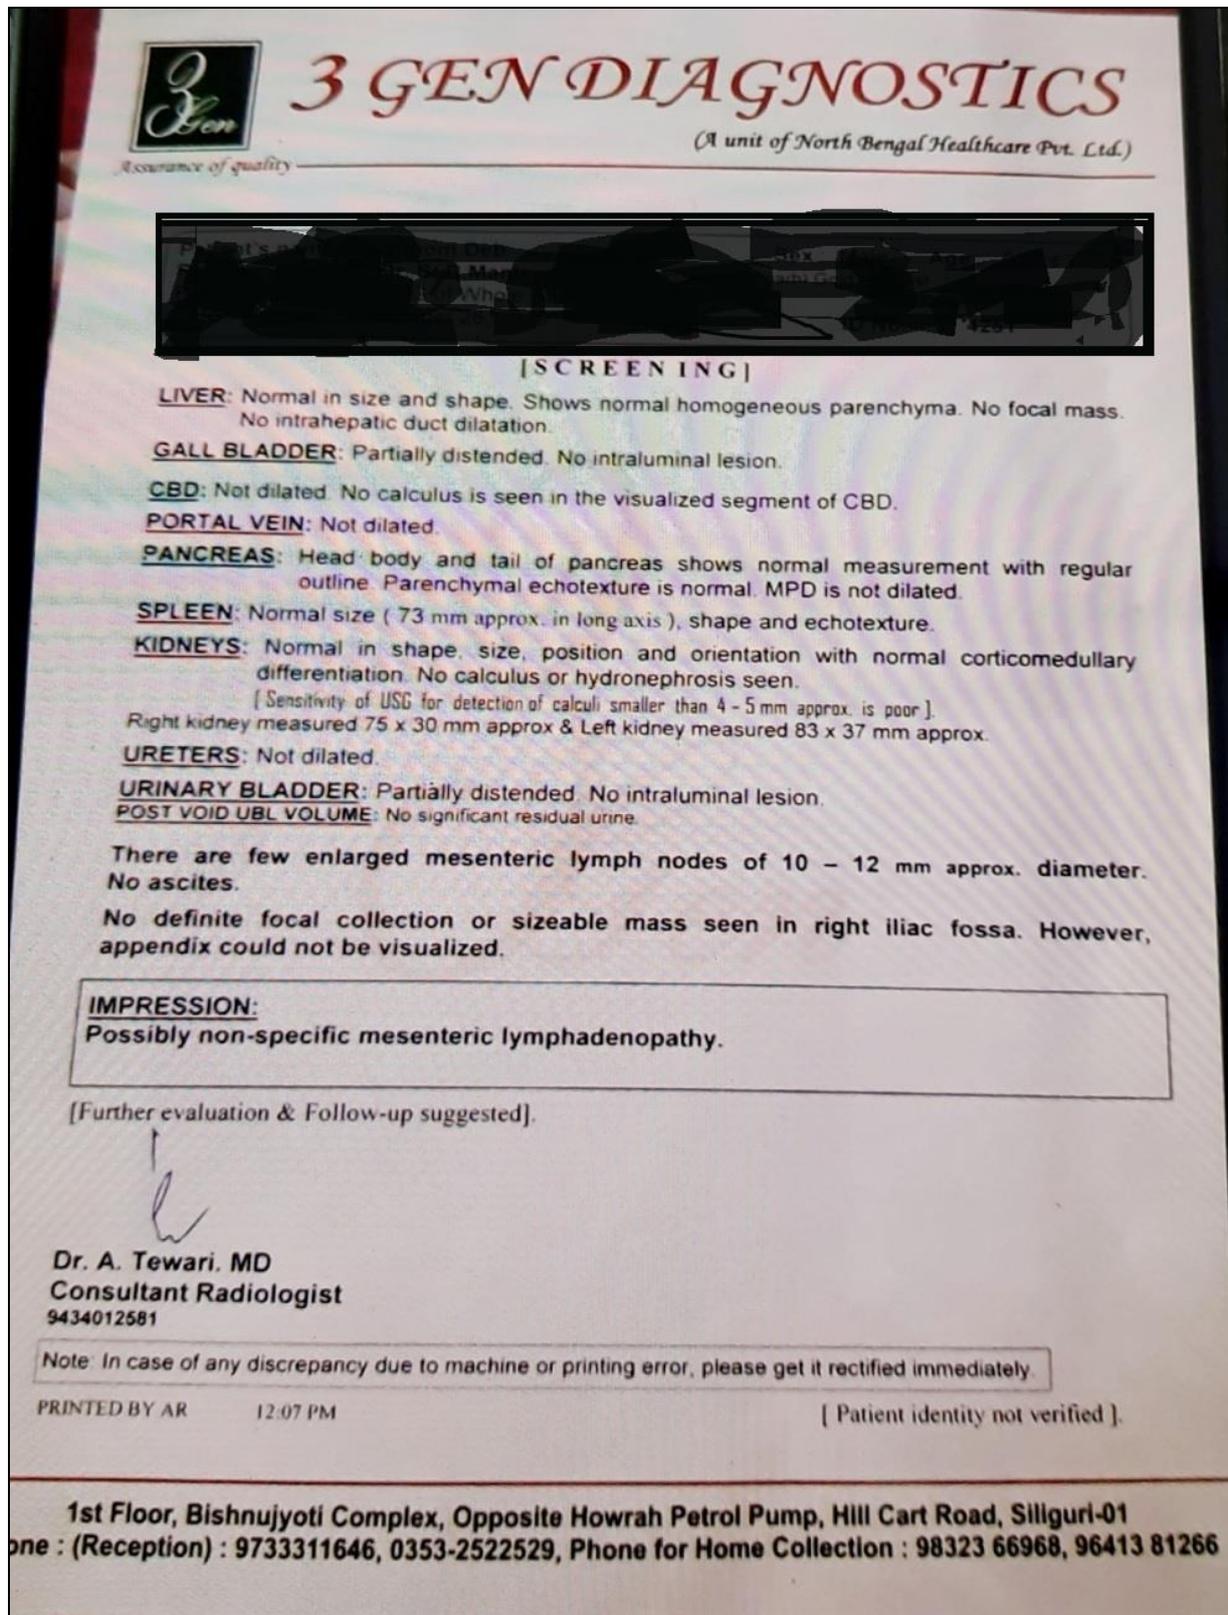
Report of Ultra-Sonography of the whole abdomen before treatment done on 26<sup>th</sup> of December, 2019.
